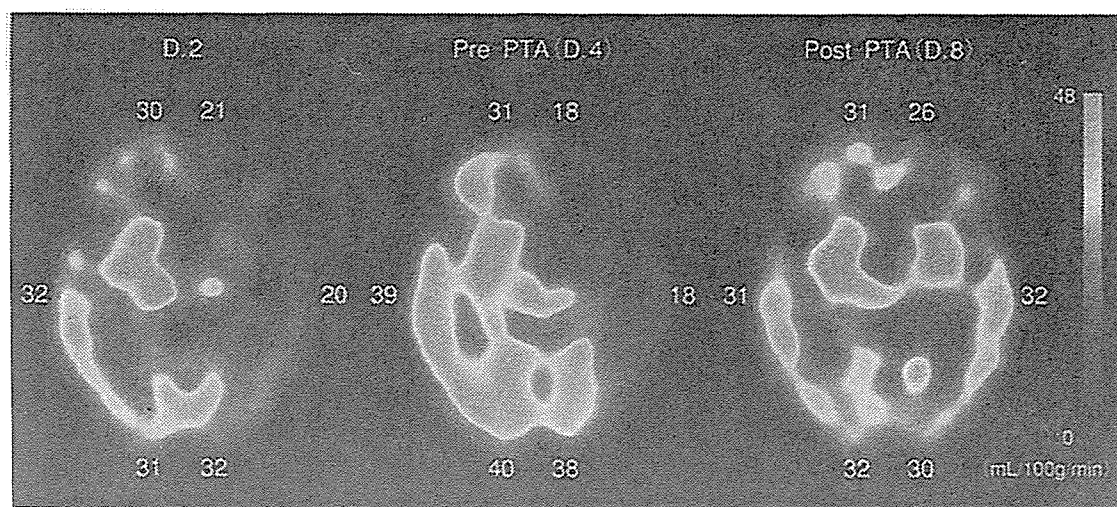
PTAにより改善がみられた内頸動脈狭窄性病変症例の脳血流SPECT (2)
